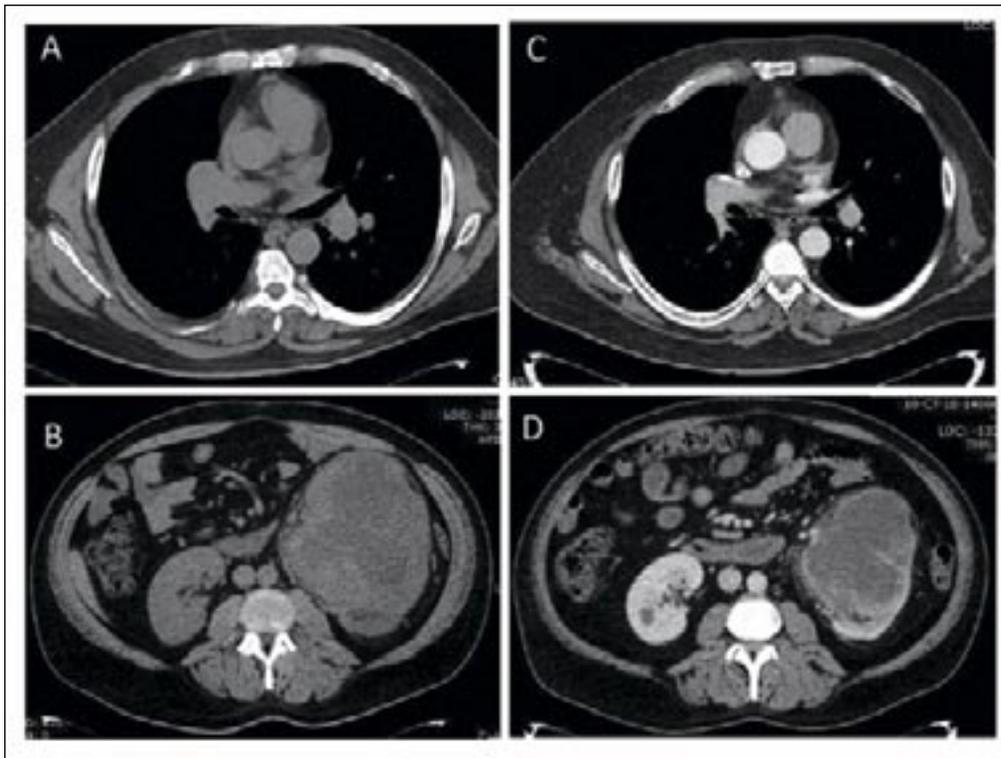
CT CAP. Panel A and B. Axial images of CT CAP showed right sided hilar lymphadenopathy and a large left kidney mass. Panel C and D. Axial images of CT CAP showed improvement in right sided hilar lymphadenopathy and reduction in size of left kidney mass, after 8 weeks of therapy with cabozantinib.
